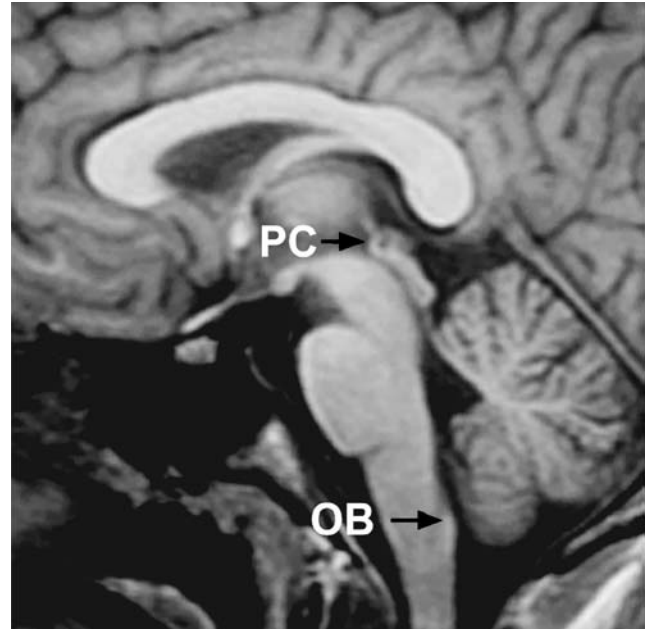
Highlight of a mid-sagittal MR image showing the PC-OB anatomical details
